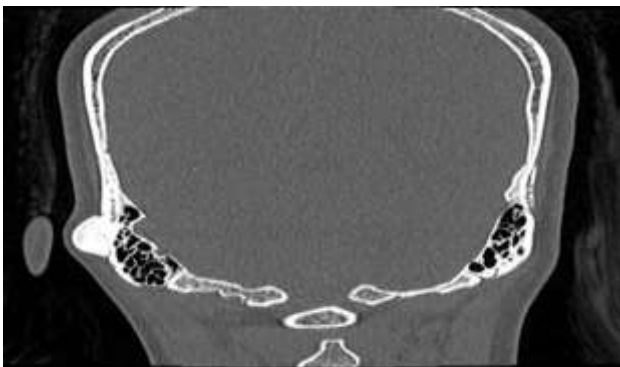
Non contrast CT scan coronal view showing osteoma of right mastoid.
